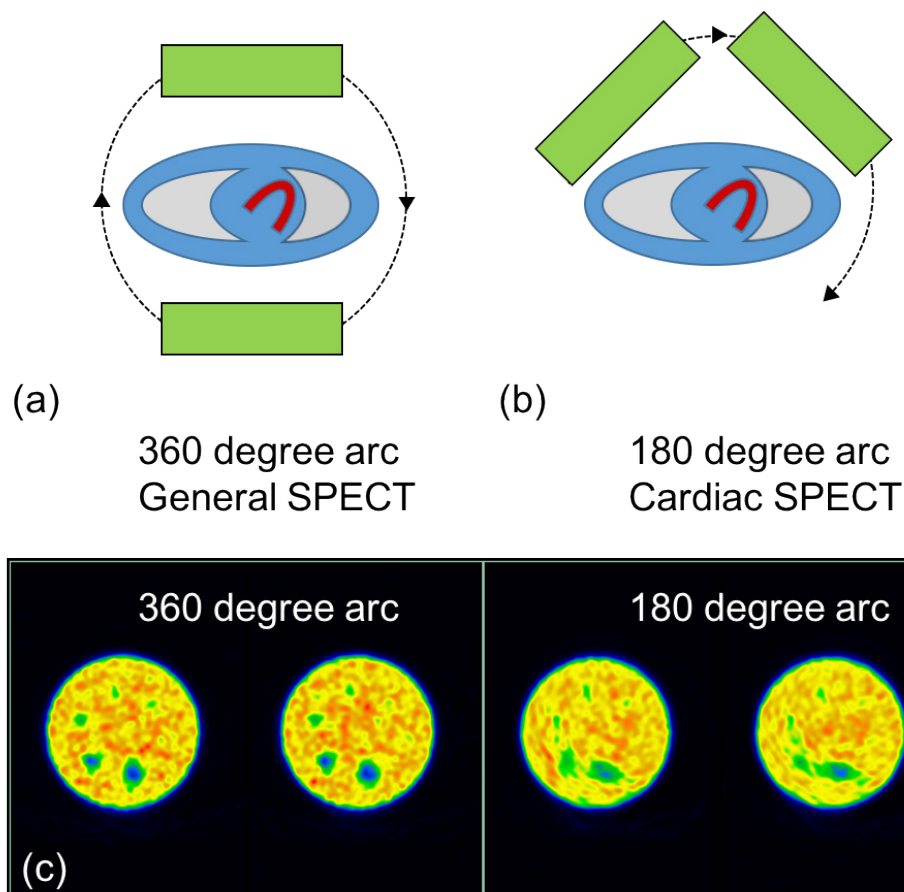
(a) The standard position for SPECT on a dual detector system is for each detector opposed to each other with each detector travelling through 180 degrees to acquire over 360 degrees of arc. (b) In nuclear cardiology, a right angle (L-mode) approach is commonly used to acquire data over 180 degrees of arc. (c) Acquiring over 180 degrees of arc can lead to distortion in areas distant to the acquired projections.
